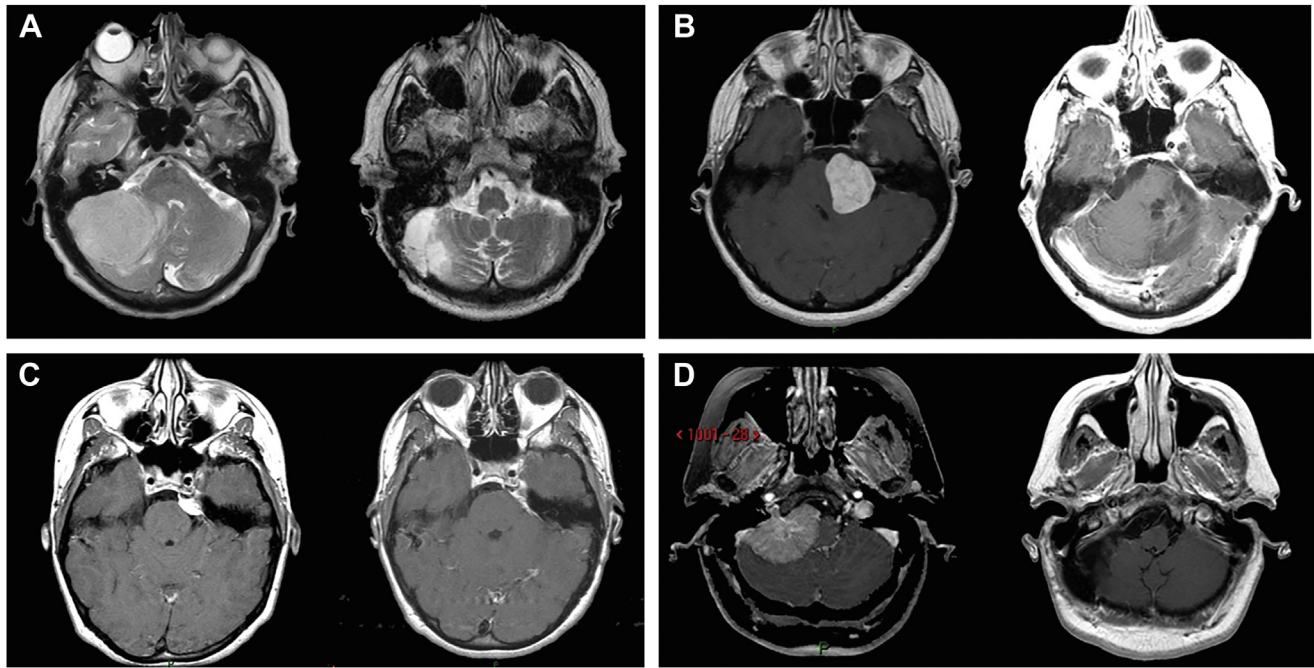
Magnetic resonance imaging of posterior petrous meningioma (PPM). (A) Type A PPM: preoperative (left) and 1-month postoperative (right) images showing near-total resection (Simpson grade 1). (B) Type B PPM: preoperative (left) and 1-month postoperative (right) images showing near-total resection (Simpson grade 2) and reactive linear dural enhancement. (C) Type C PPM: preoperative (left) and 1-month
